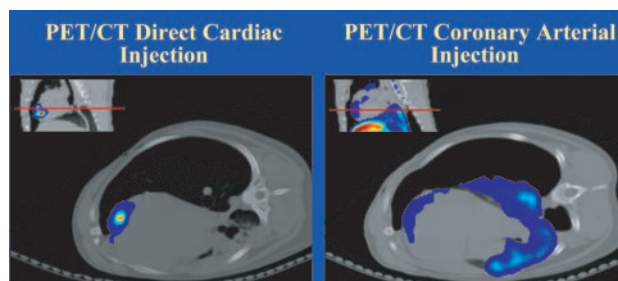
PET/CT and MRI were used to track stem cell distribution in myocardial stem cell therapy, showing that distribution patterns differed with site of injection.
